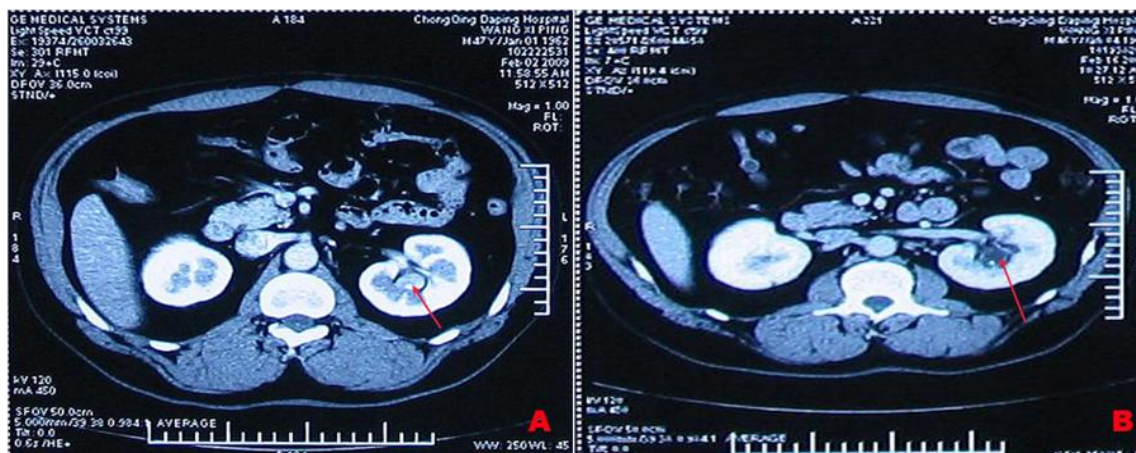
CT of bilateral kidneys showed left kidney stone, space occupying lesion in the left renal pelvis suggesting renal pelvis cancer (arrow); B, CT of bilateral kidneys showed left kidney stone but space occupying lesion was absent in the renal pelvis (arrow).
